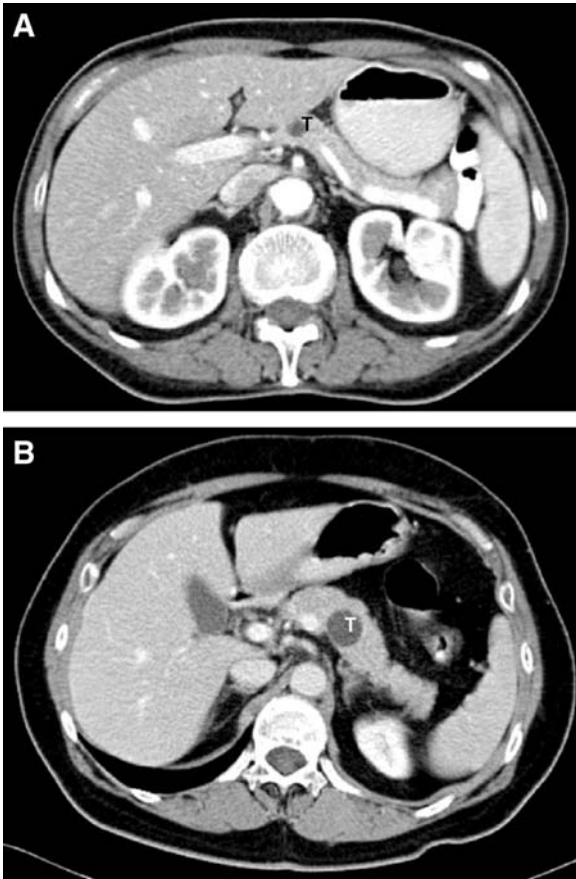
CT images of tumors located in the neck (A) and body (B). They belong respectively to patients 5 and 4. Tumors are indicated with T.
